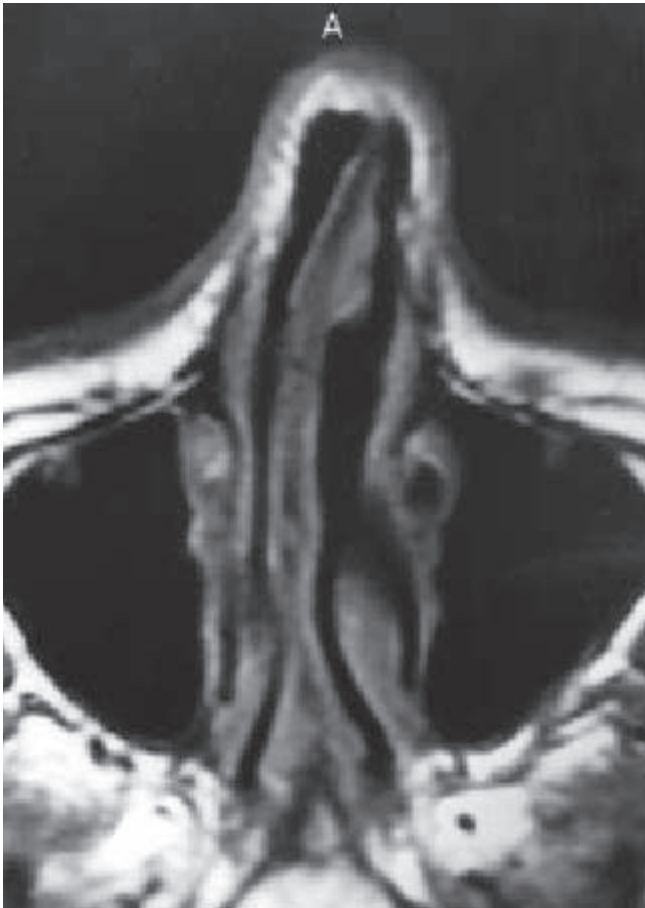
T1-weighted axial MRI showing tumor was located on the left nasal septum.
